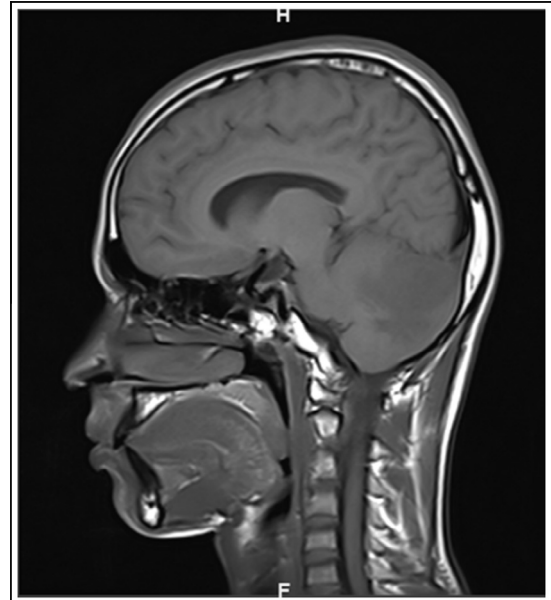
MRI T1 sagittal view showing hypo intense lesion with surrounding edema in the cerebellum.
